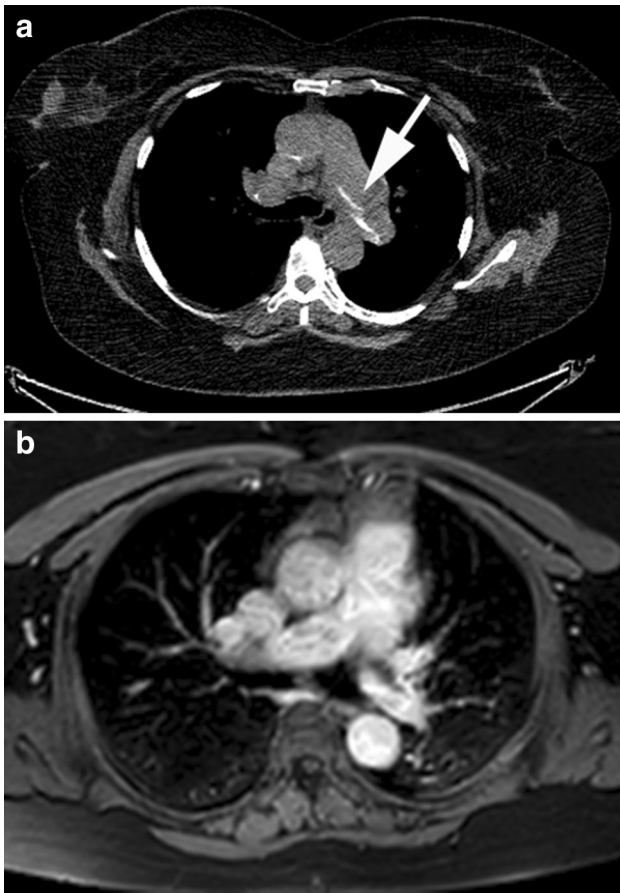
68-year-old man with chronic pulmonary embolism. a Axial CT of the chest demonstrates chronic calcified thrombi in the left and right main pulmonary arteries (arrow). b Axial post contrast MR image demonstrating left main pulmonary artery eccentric thrombus
